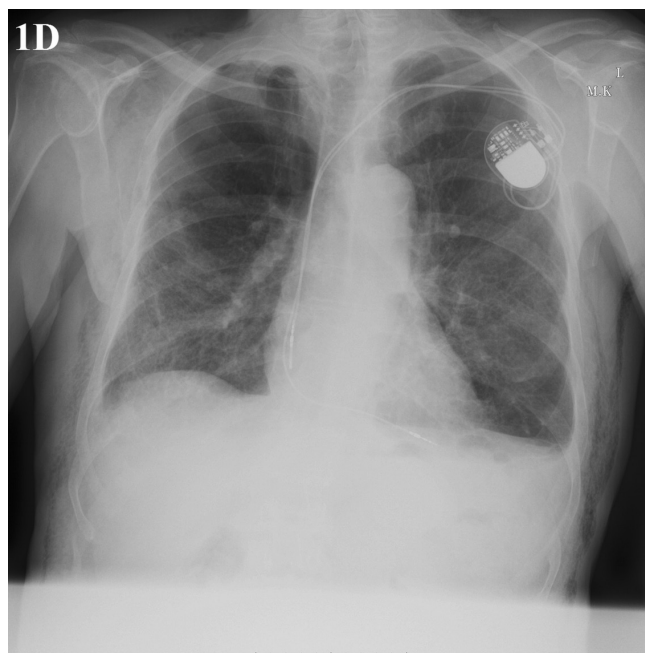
Chest x-ray after 14 days — visible significant reduction of subcutaneous emphysema.
